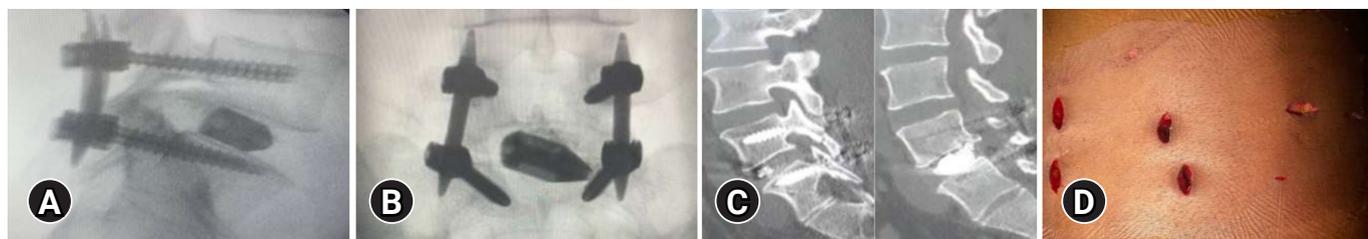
(A) Intra-op C arm image lateral view. (B) intra-op C arm image AP view. (C) Post-op CT sagittal view showing pedicle screws and inter body cage. (D) Post-op skin incisions.
